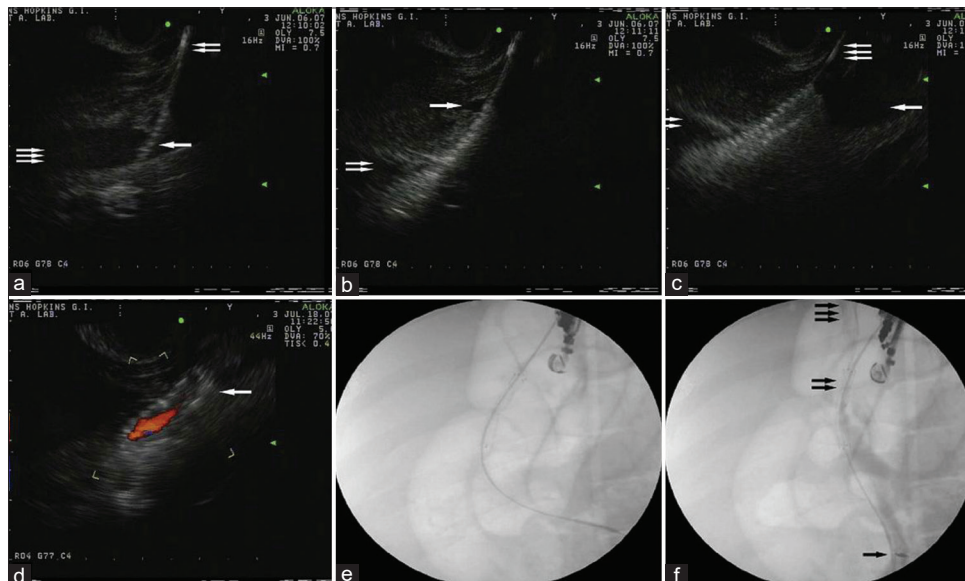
Endoscopic ultrasound and fluoroscopic view of endoscopic ultrasound-guided transjugular intrahepatic portosystemic shunt. (a) The stent (one arrow) is advanced over the guidewire (two arrows) into the HV (three arrows) and (b) deployment of the stent started from its distal end. The stent was inside the HV (one arrow) and the PV (two arrows), (c) the stent was fully deployed inside the HV (one arrow) and the PV (two arrows) over the guidewire (three arrows), (d) fluoroscopic view showing the stent was fully deployed, (e) endoscopic ultrasound with color Doppler demonstrating blood flow through the fully deployed stent (one arrow), (f) fluoroscopy demonstrated the flow of contrast injected into the PV (one arrow) through the stent (two arrows) and into the HV (three arrows) (reprinted with permission from Elsevier)
